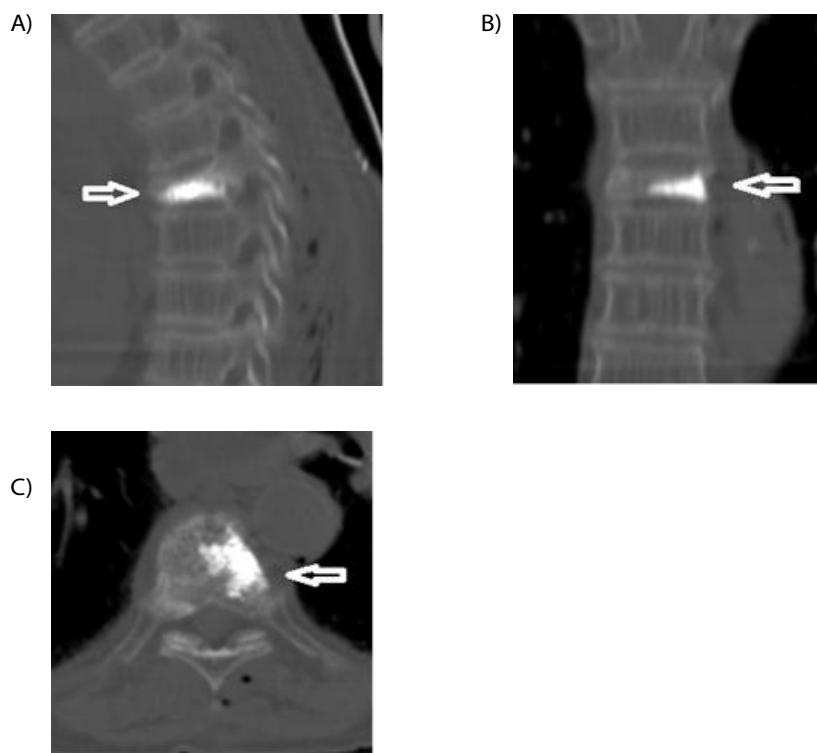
Sight of the T7 vertebrae after PMMA injection on sagittal (A), coronal (B) ve axial (C) CT images.
